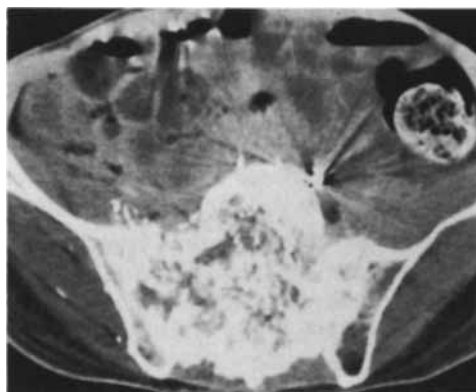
Computed tomography of the lumbosacral area 18 months following implantation. Complete calcification within the tumor-bearing area and reconstruction of previously destroyed bone.
